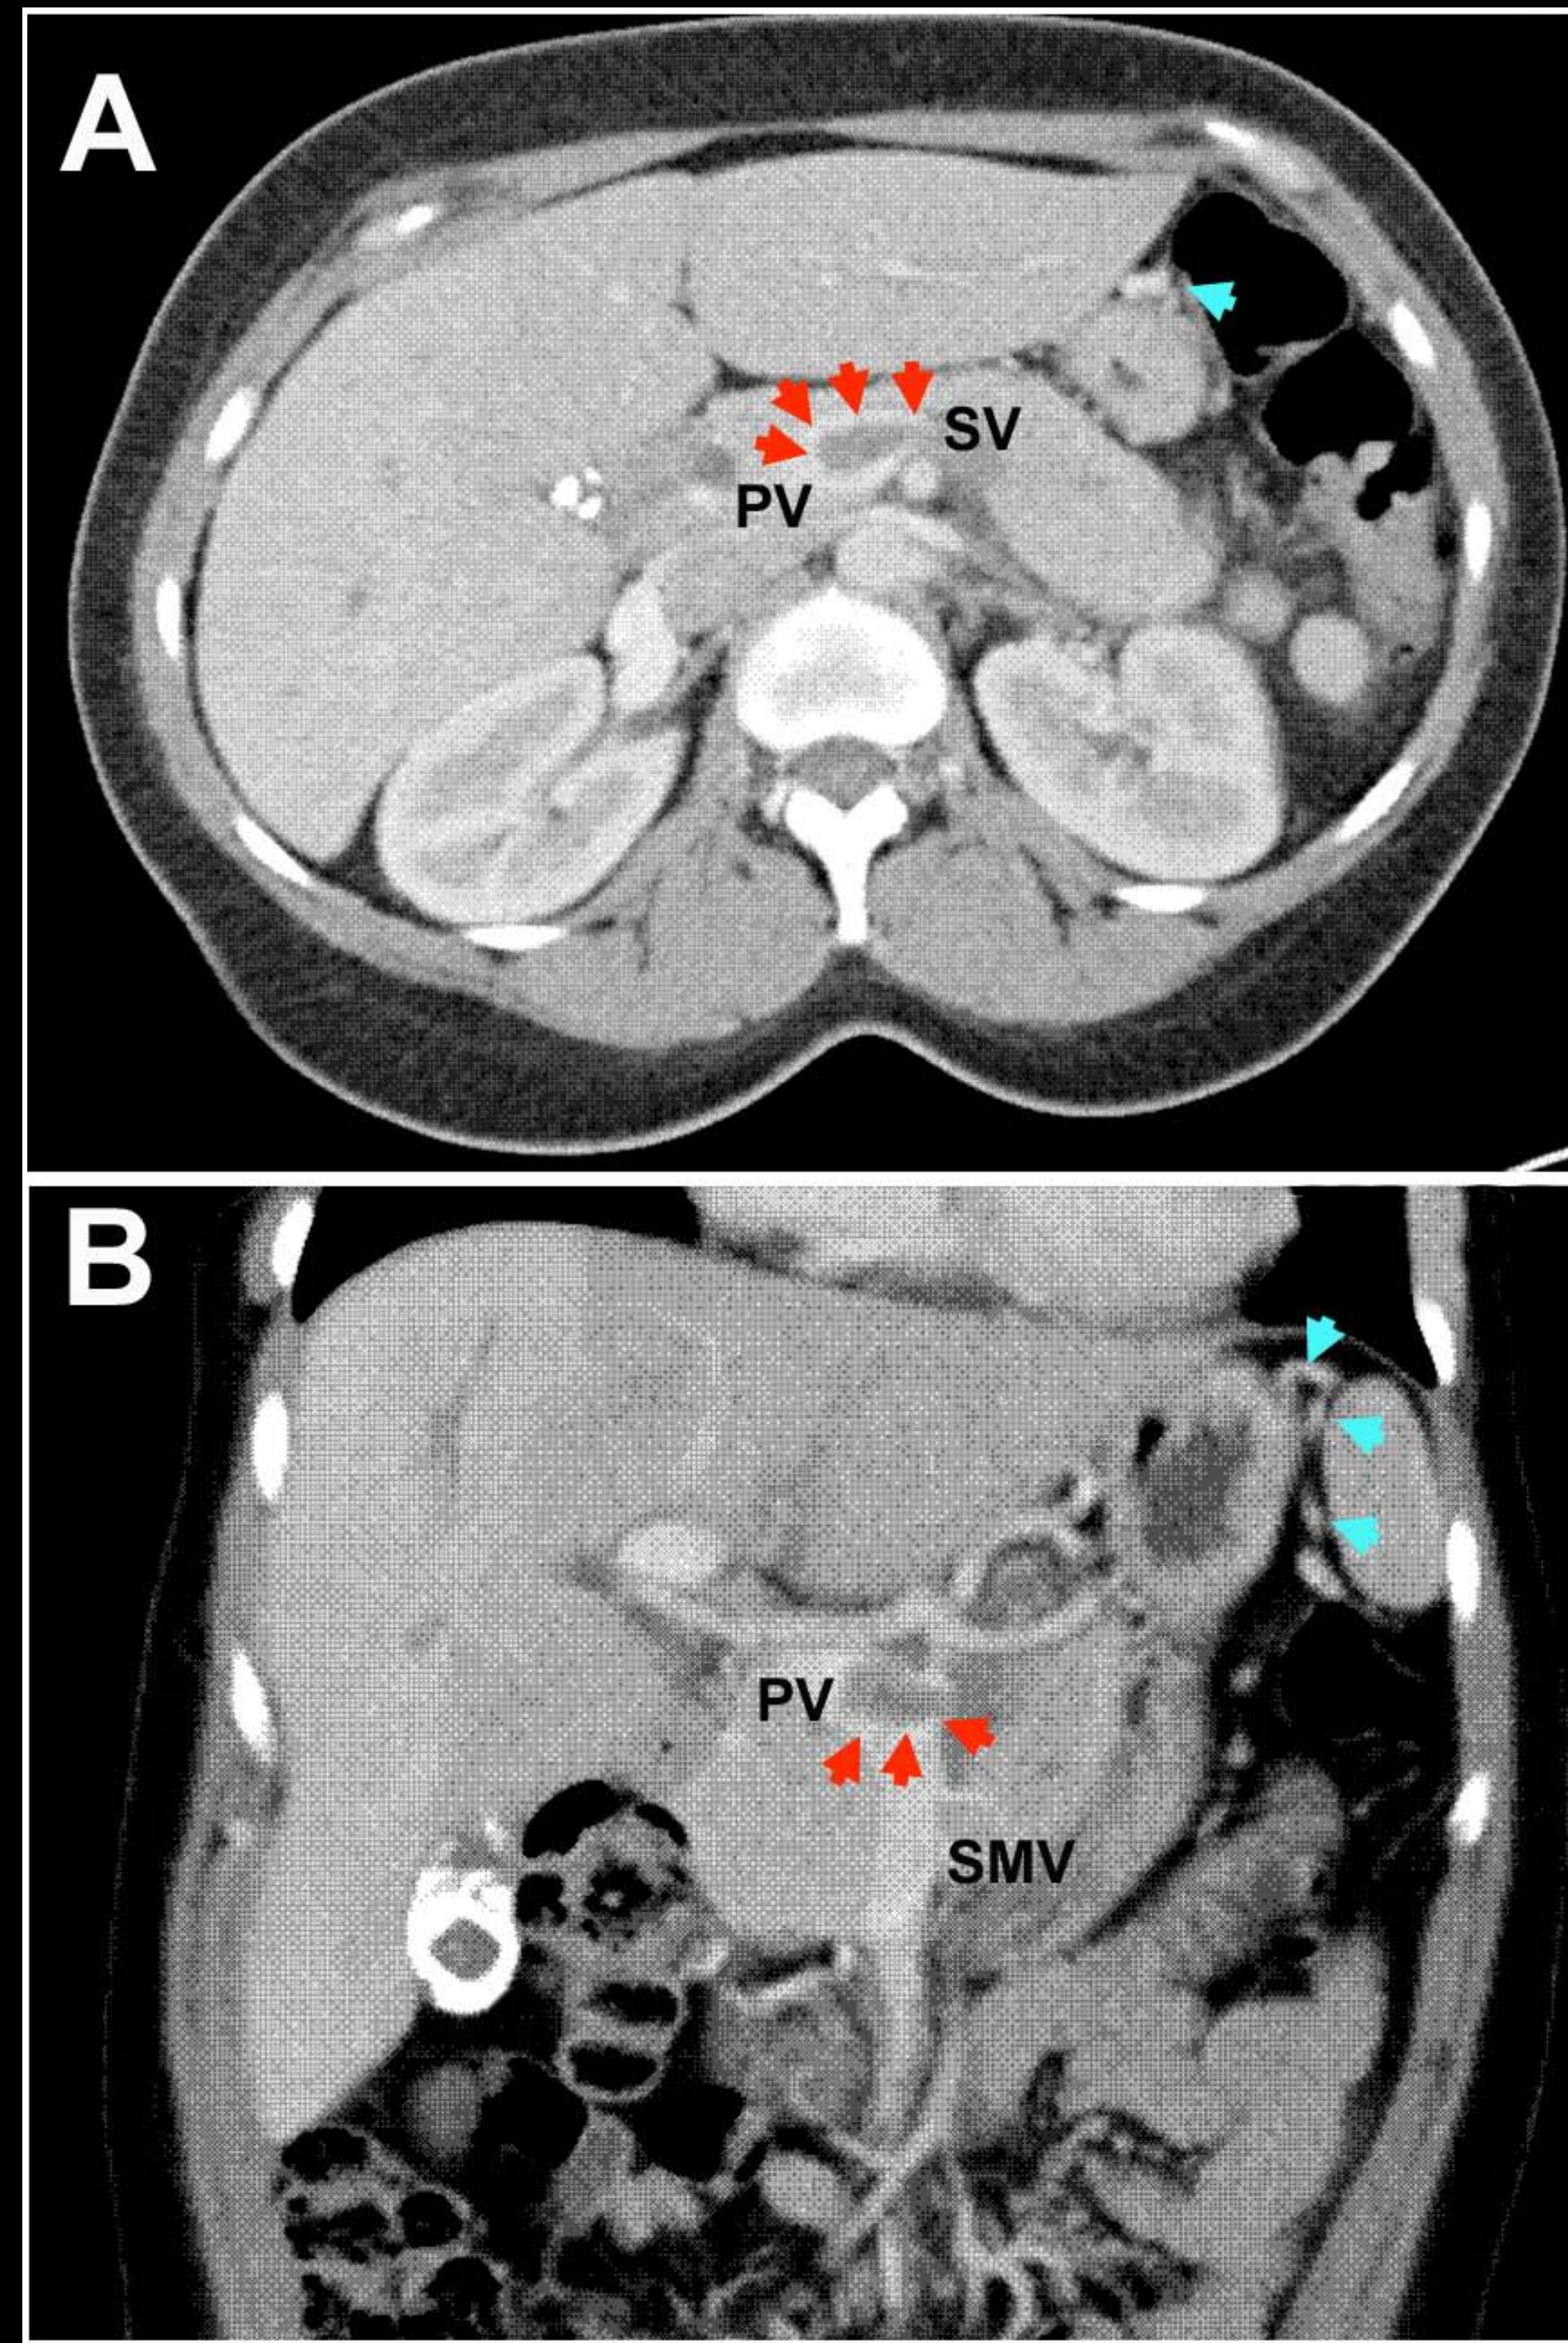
CT of abdomen demonstrating porto-splenic vein thrombosis. The clot (red arrowheads) extends into the portal vein (PV) from its origin in the splenic vein (SV). Venous collateral formation is apparent (blue arrowheads). superior mesenteric vein (SMV) was patent. Cross section is presented in A, and coronal view is presented in B.
